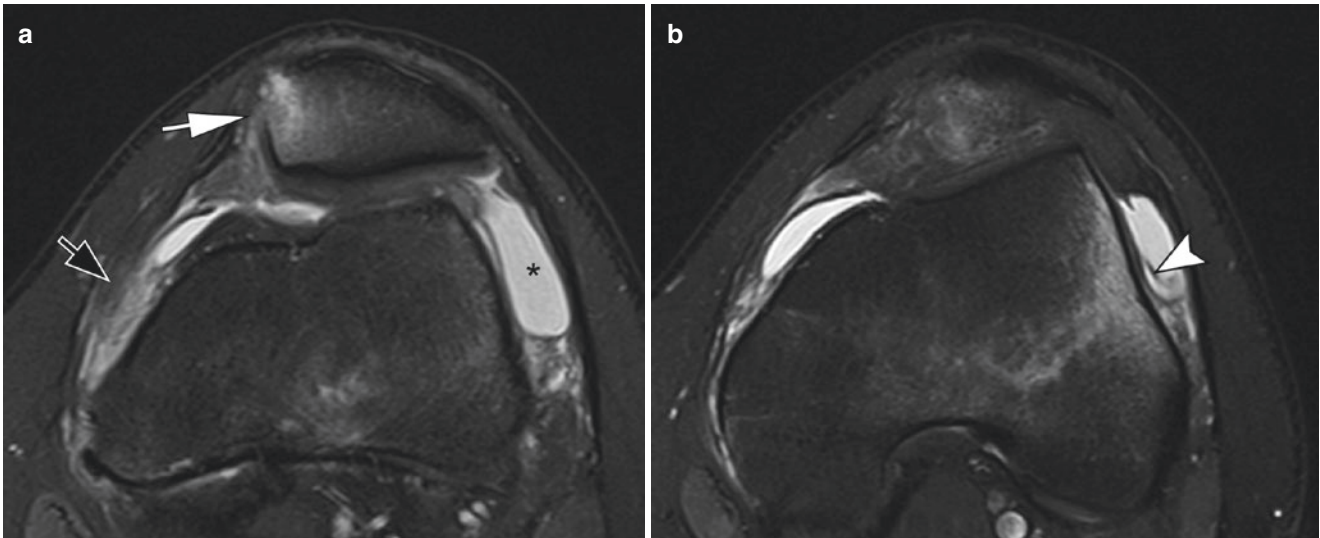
Lateral patellar dislocation. Axial T2-weighted images of the knee with fat suppression. (a) Bone impaction with marrow edema at the medial facet of the patella (white arrow) and strain of the proximal
